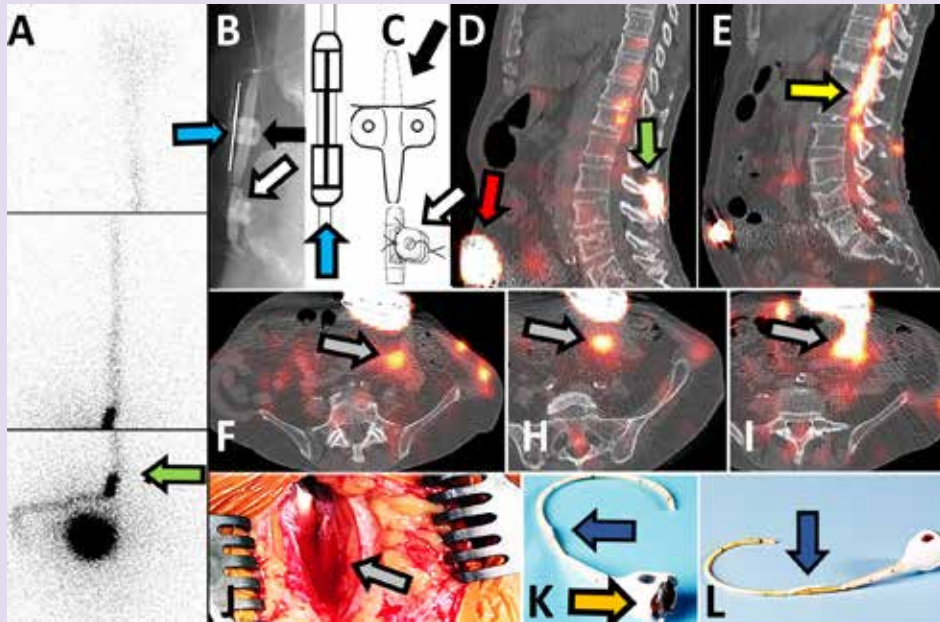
Sheared catheter and leakage in the pump pocket in a 59-year-old male with spasticity with a spinal cord lesion at T5. Dorsal tracer accumulation in the drug delivery system parts (A, green arrow) including needle-shaped catheter-catheter connector (B,C, blue arrows), anchor (B,C, black arrow) and retained old-type anchor (B,C, white arrow). Enhanced tracer activity at the abdominal/lumbar transition (A, lower row) with limited tracer activity in the cerebral cisterns (A, upper row) was suspicious for catheter obstruction. SPECT-CT fusion images show enlargement of the pump shape (D, red arrow) and some fluid outside the pump pocket (F-I, gray arrows). At surgery fluid in the pump pocket was identified (J, gray arrow) caused by a sheared catheter. Also, at surgery a catheter obstruction was found. Post-explantation image of the system showed a catheter-pump connector distortion (K, orange arrow) and a sheared catheter (K,L, purple arrow).
